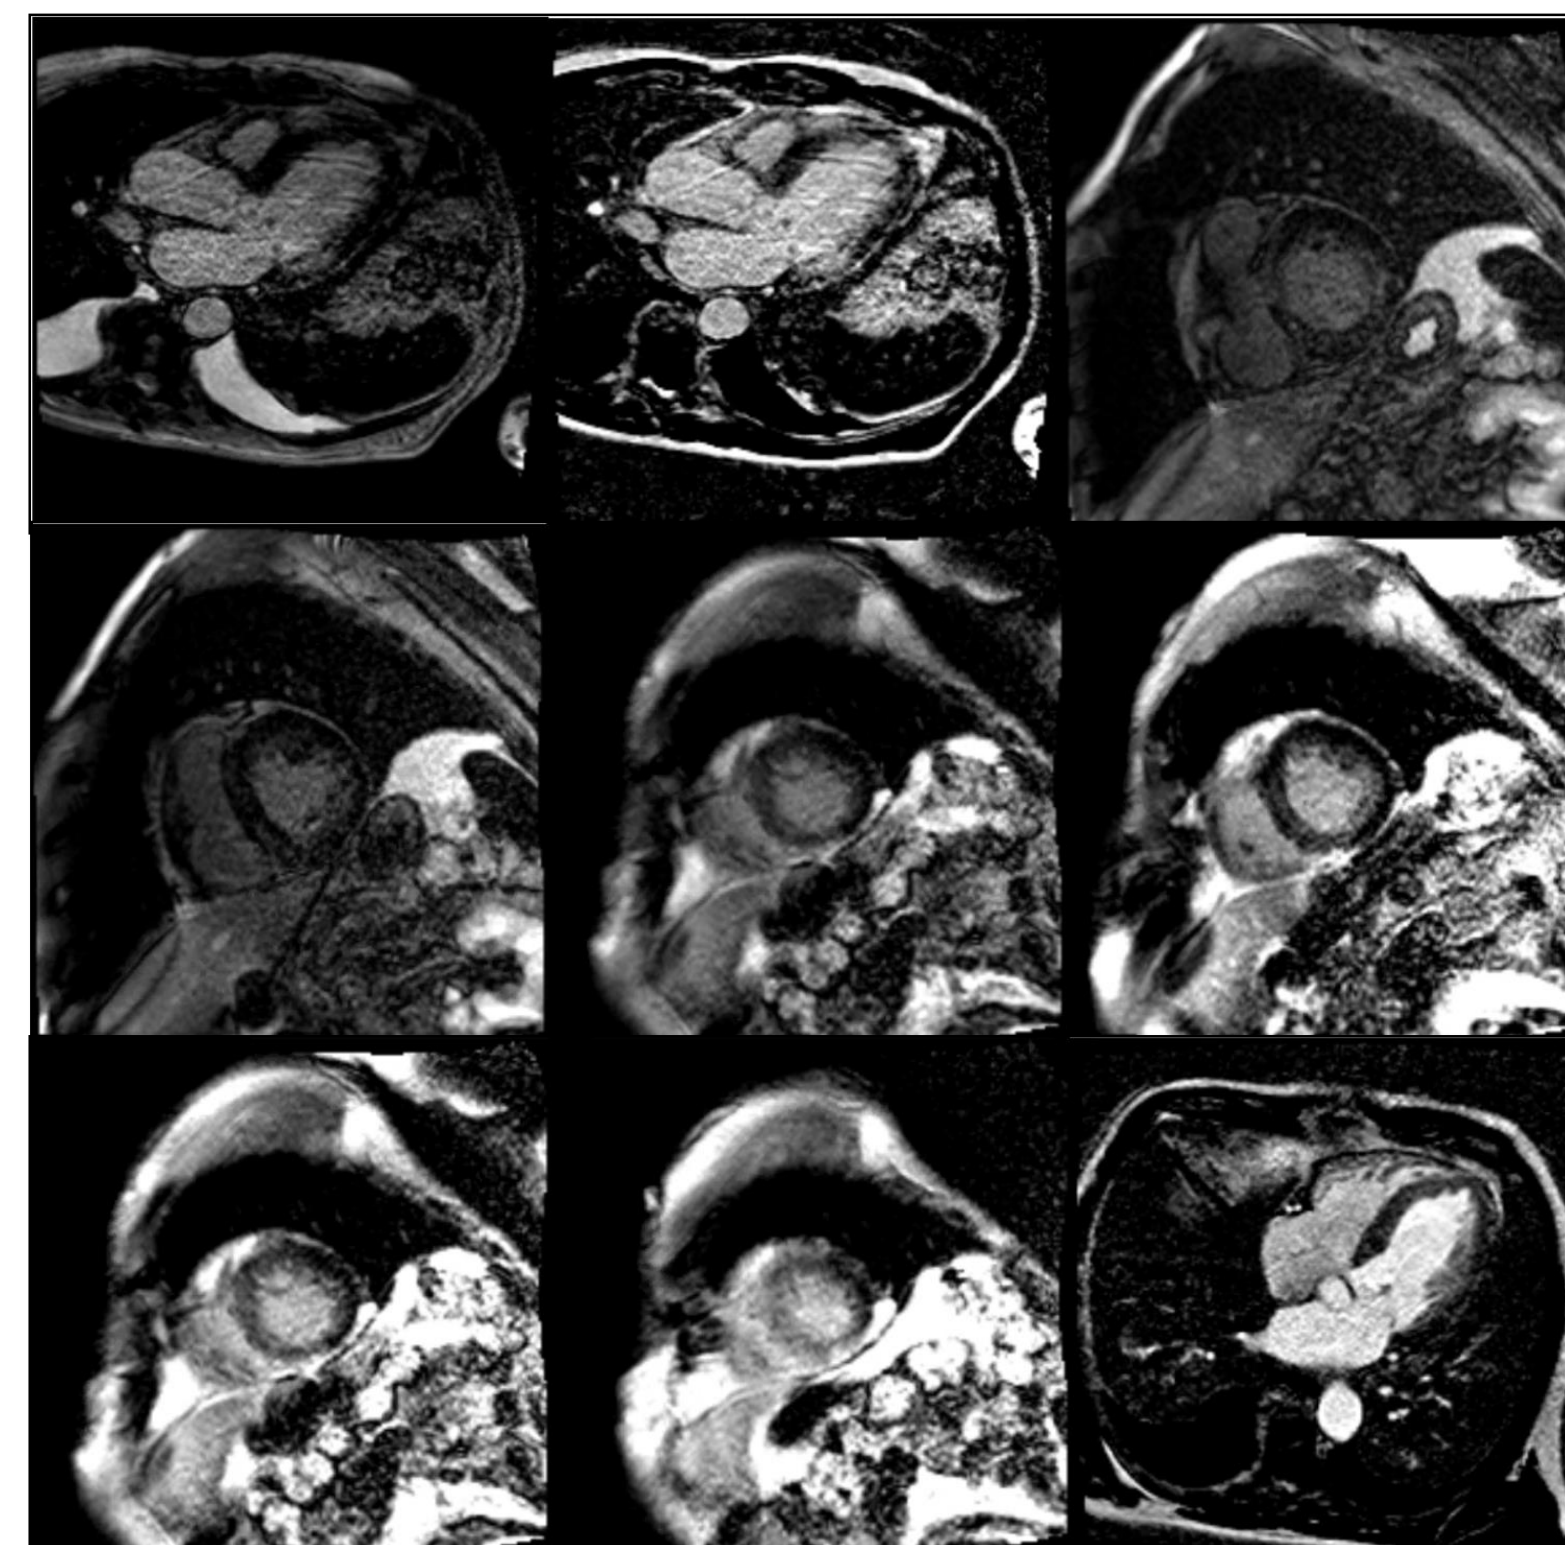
Cardiac MRI. The left ventricle is dilated with global hypokinesis and EF of 32%. Evidence of LGE with a mottled mid wall pattern in the distal septum and basal inferolateral segment (non-ischemic pattern representing myocardial edema or interstitial fibrosis).
